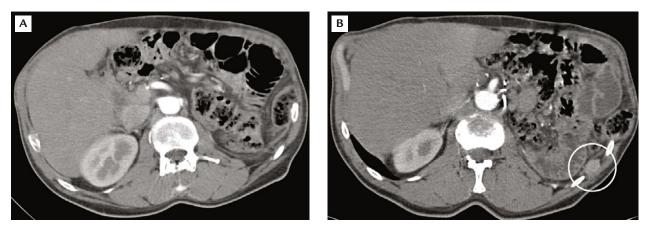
Computed tomography scan showing the initial regular follow-up at 12 months (left) and 20 months (right) with the newly diagnosed solid tumor-suspicious mass in the left retroperitoneum (white circle).
